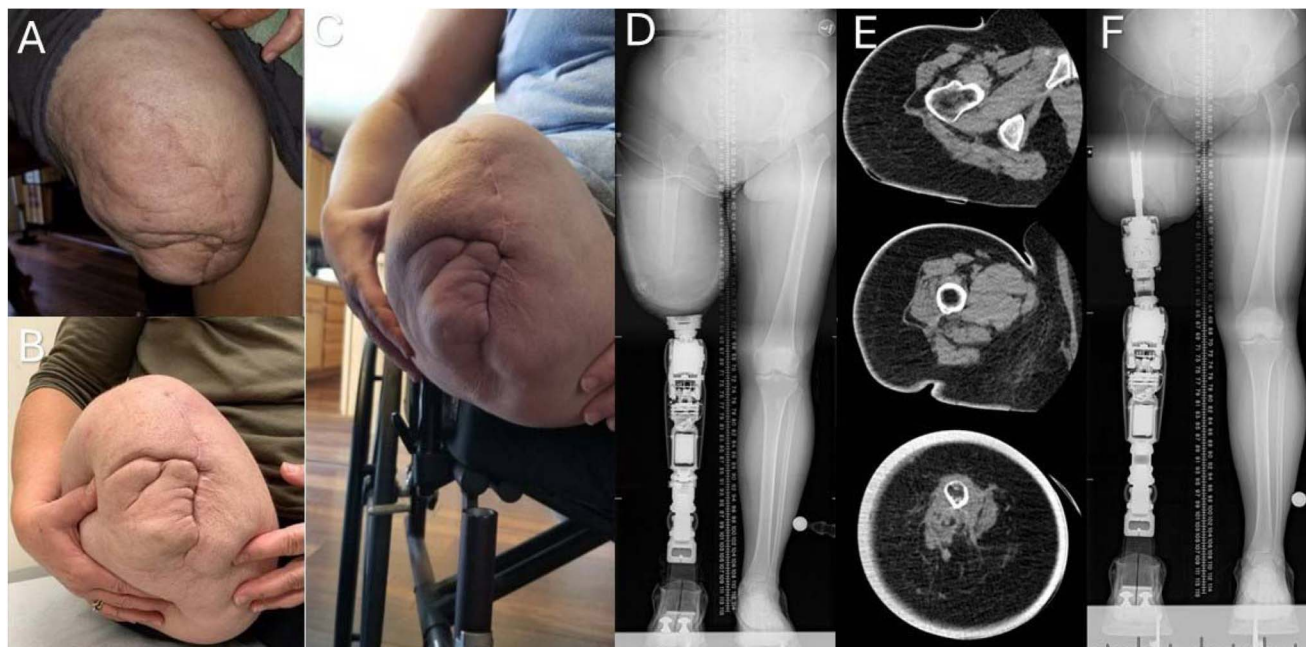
(A–C) Routine physical examination of the residual limb and adjacent joint in a patient with unilateral transfemoral amputation. (D) Radiographs (standing hip-to-ankle X-ray with prosthesis) of a patient with unilateral transfemoral amputation using a socket prosthesis. (E) Axial CT scan of the right transfemoral residual bone assessing intramedullary canal integrity and diameter. (F) Radiographs (standing hip-to-ankle X-ray with an OPRA implant and BAL prosthesis) showing a unilateral osseointegrated OPRA implant in the residual femur attached to a prosthetic leg.
